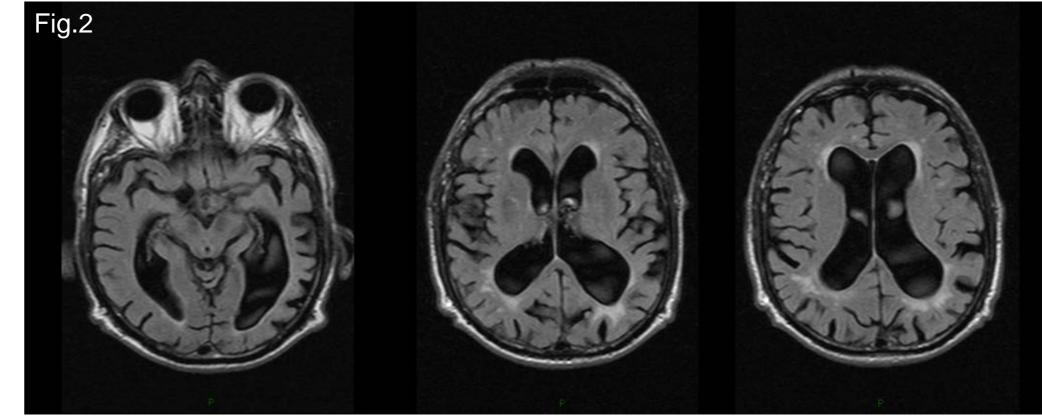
Brain MRI (PRE) showing a marked cortical atrophy, particularly of parietaitemporal-insular regions, and aspecific periventricular white matter abnormalities.
